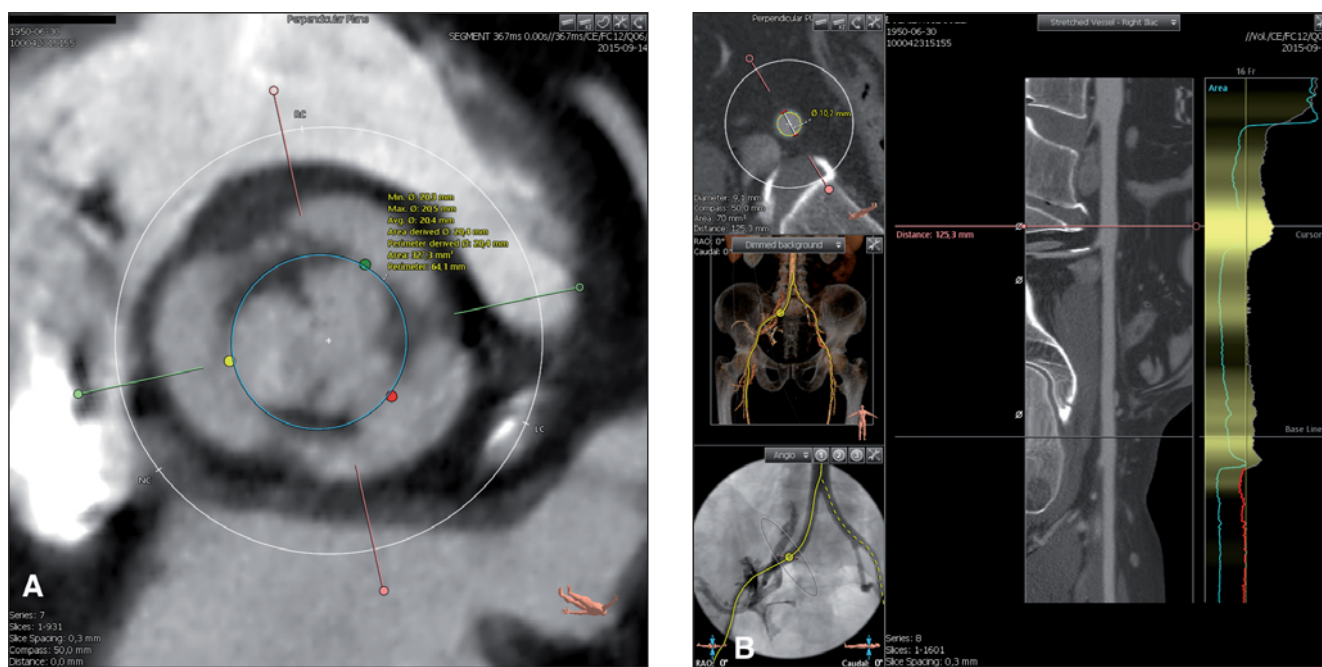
(A) Computed tomography three-dimensional multi-slice reconstruction showing aortic root measurements. (B) Computed tomography three-dimensional multi-slice reconstruction showing femoral approach assessment (3Mensio Structural Heart Medical Imaging, Bilthoven, Netherlands).
